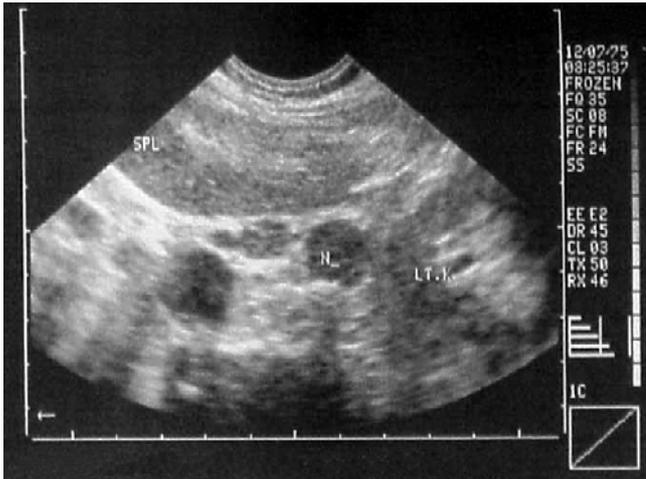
Abdominal sonography in patient 3 showing significant lymph nodes in the splenic hilum and para-aortic region.
